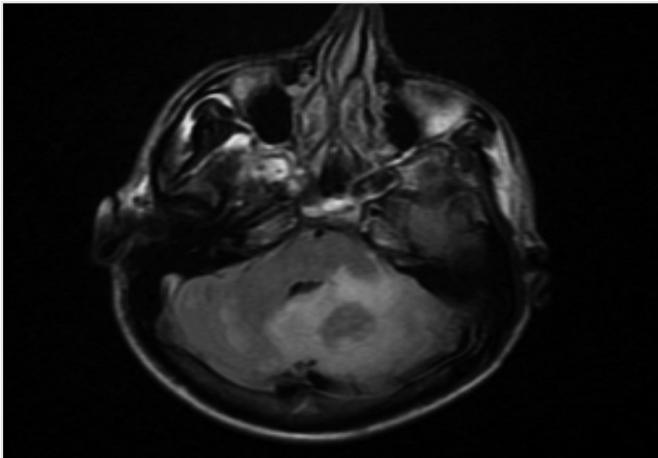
Axial T2-FLAIR images showing hyperintense lesions with edema in the cerebellum
